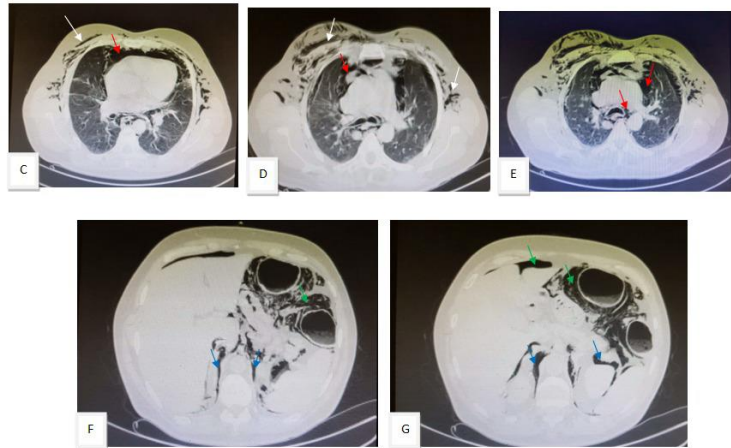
Axial plane CT scan for chest (C,D, and E) and abdomen (F and G) in lung window, showed: Extensive subcutaneous emphysema tracks along the superior aspect of the anterior thoracic wall(white arrow). Extensive pneumomediastinum (red arrow) that extends into the retroperitoneum (blue arrow). Pneumomediastinum is also partially imaged (green arrow)
